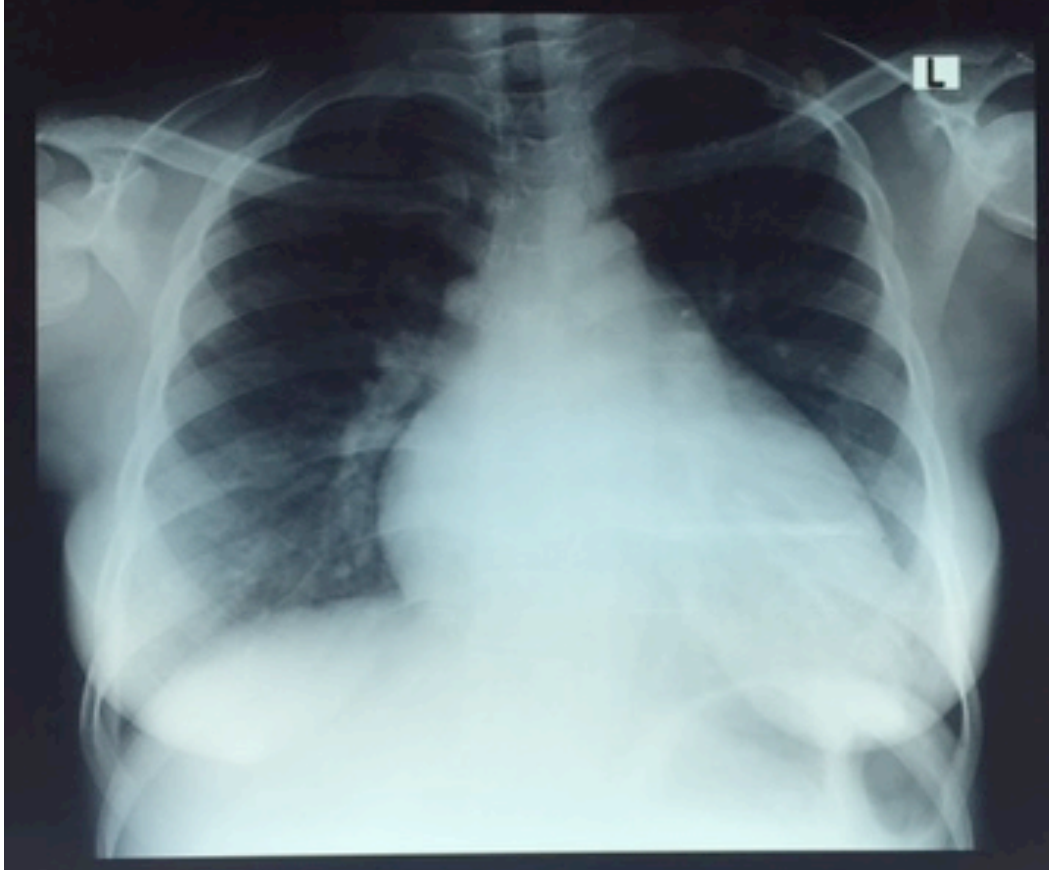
A postero-anterior chest X-ray
